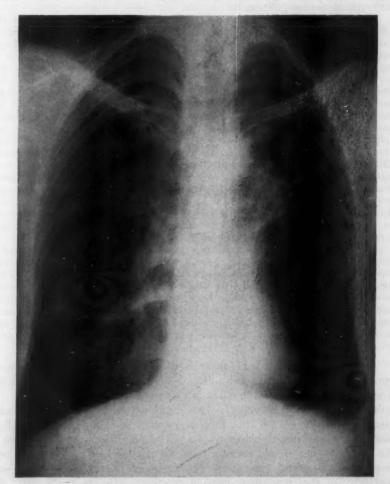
Case 4. Chest x-ray one year after the third course of hydroxystilbamidine. Note prominent emphysema of the left lower lobe and bilateral fibrosis.
